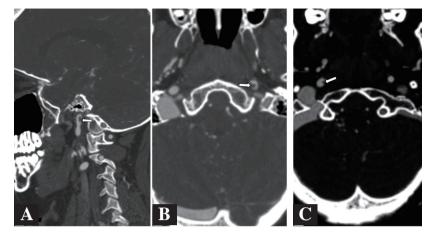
CT angiogram (A) sagittal reconstruction and (B) axial images showing eccentric thrombus (arrow) in the petrous segment of left ICA and (C) axial image showing small eccentric thrombus (arrow) in the right cervical ICA
